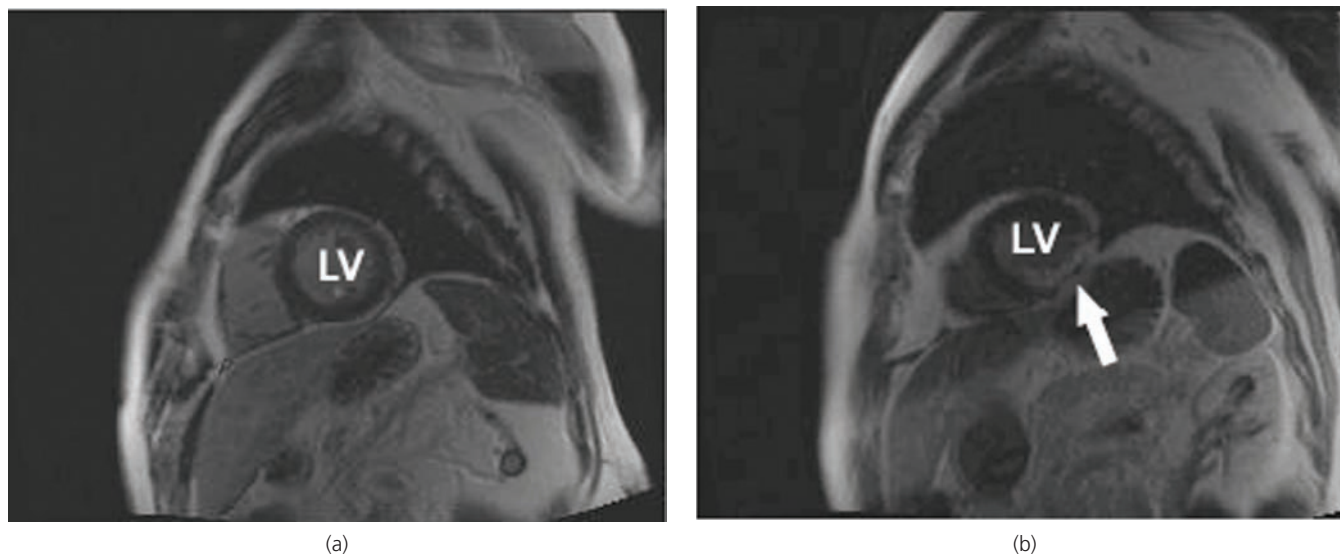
(a) Cardiac magnetic resonance image of a normal heart showing circular LV in a short axis view. (b) Inferior and inferolateral LV scarring due to right coronary artery occlusion. Contrast enhancement of the infarcted myocardium is seen (arrow) following intravenous administration of a gadolinium chelate, which diffuses into interstitium (infarcted myocardium) but not myocardial cells. The increased concentration of gadolinium in infarcted myocardium results in hyper-enhancement. LV, left ventricle.
